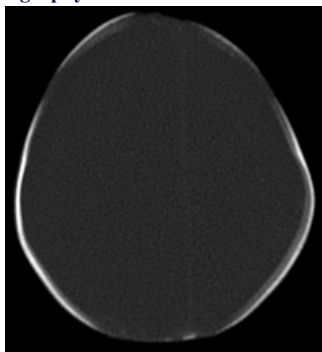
Plain CT Brain axial section (Bone window) - Increased head circumference with severe thinning of both outer and inner tables of the calvarium and wide fontanelles.
